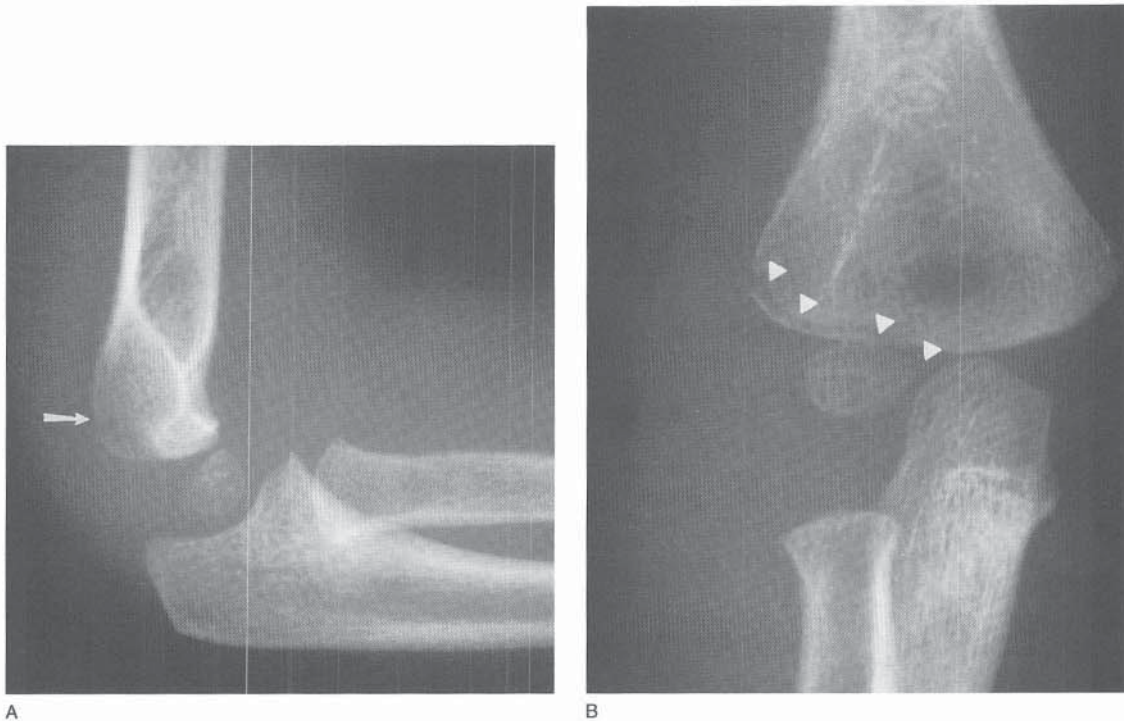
A, Lateral radiograph of a minimally displaced lateral condyle fracture. The small, posteriorly displaced metaphyseal fragment (*arrow*) is often difficult to see. B, AP radiograph demonstrating the fracture line (*arrowheads*) running parallel to the physis. The fracture extends across the physis into the joint.
